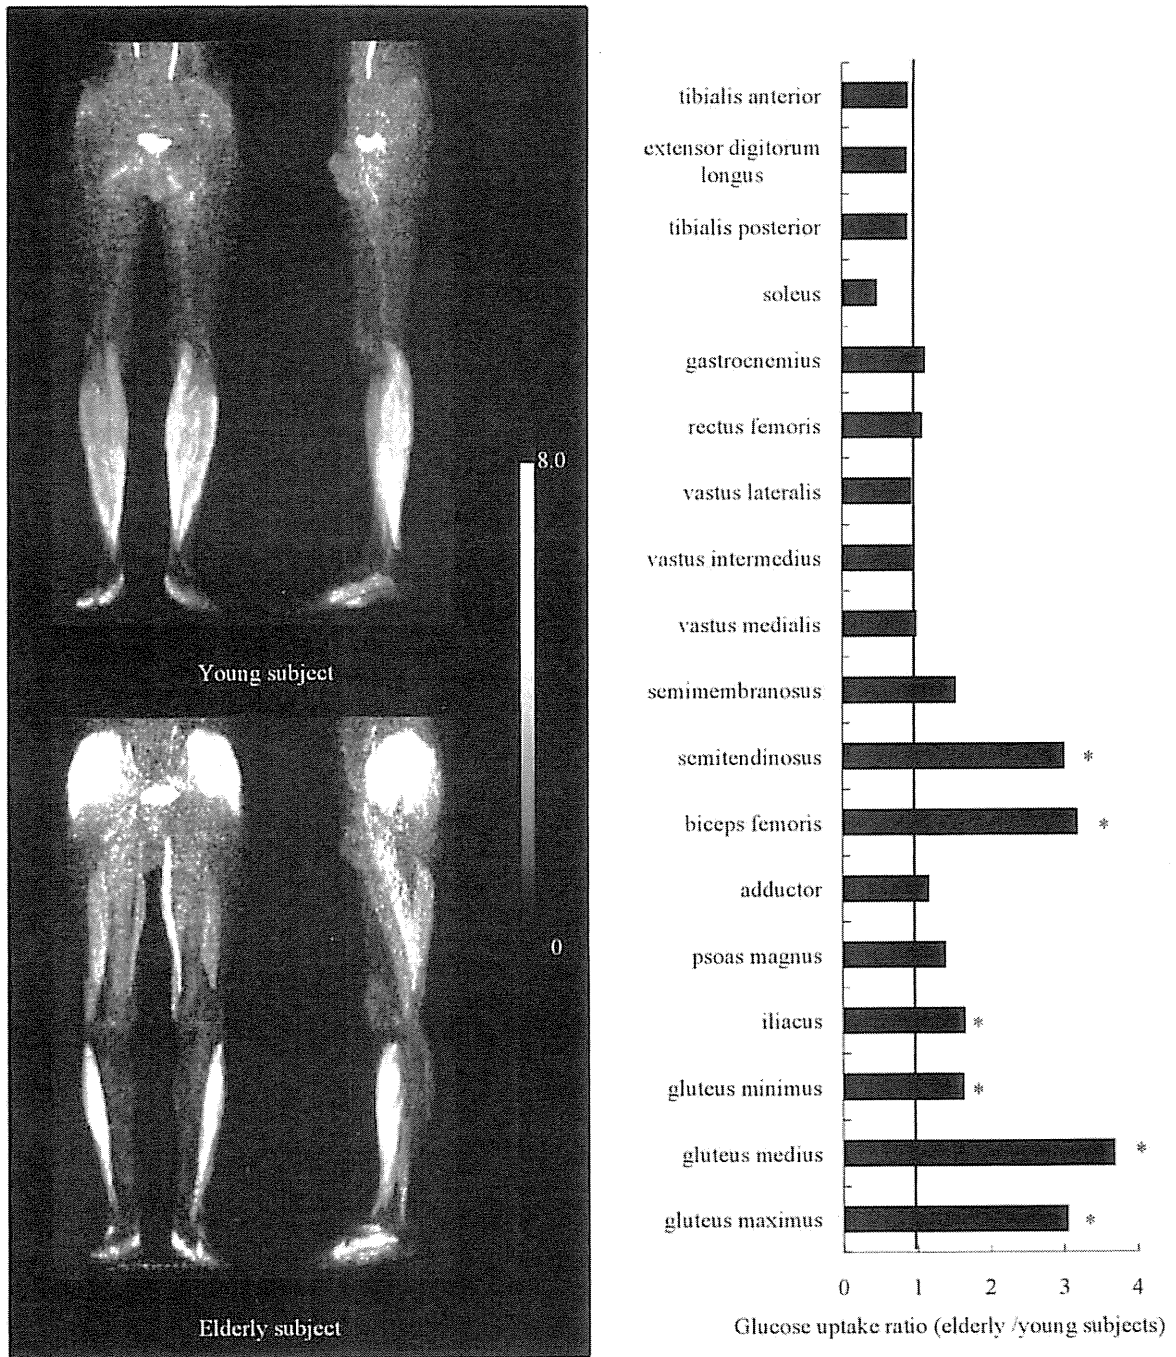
FDG PET images taken after walking in young and elderly subjects.
